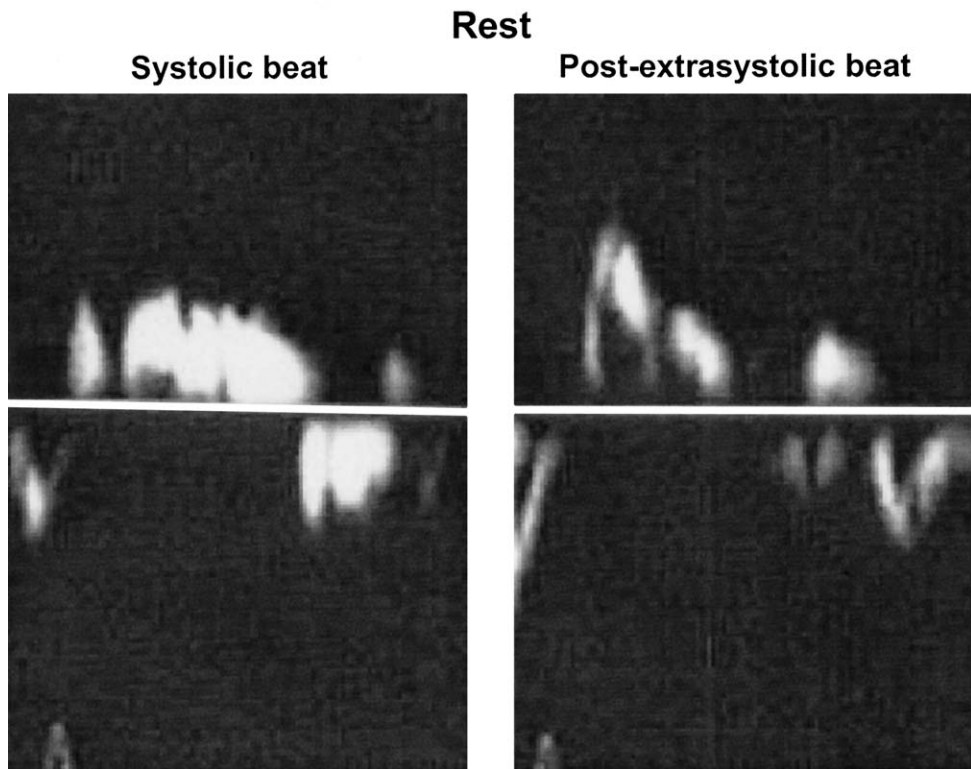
'Post-extrasystolic potentiation recruits incremental contractile reserve of dyssynergic myocardium during dobutamine stress testing: evidence by pulsed wave tissue Doppler imaging'. Riccardo Rambaldi, MD, Ph.D.
